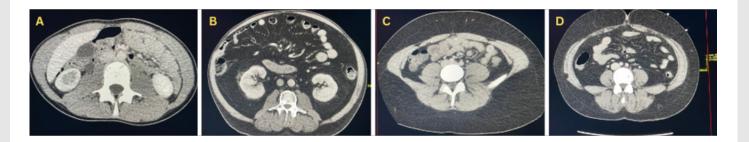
Axial CT images through mid-abdomen displaying variations in extraabdominal-subcutaneous and intraabdominal-visceral fat distribution. Image A = lean state; Image B = visceral fat dominance; Image C = subcutaneous accumulation; Image D = accumulation in both compartments.
